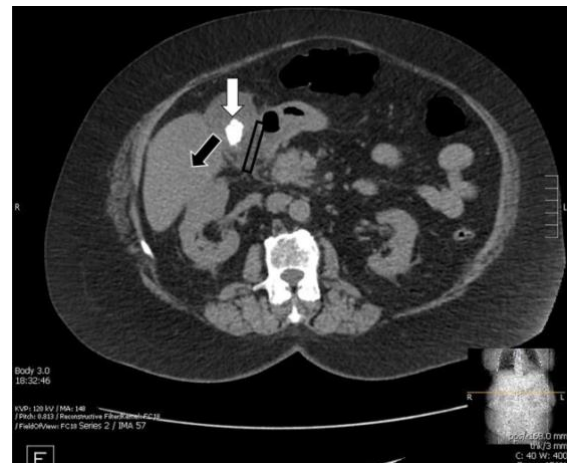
CT abdomen and pelvis without IV contrast showing cholelithiasis (white arrow). Gallbladder wall thickening (black rectangle) and moderate pericholecystic inflammation consistent with acute cholecystitis and borderline hepatic steatosis (black arrow).
